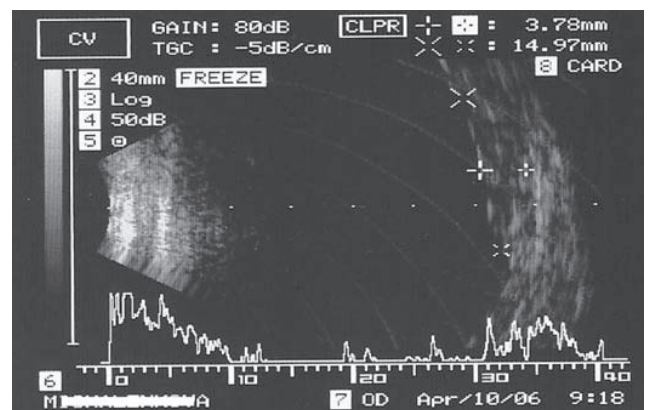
Ultrasound recording – Bscan – image of residual deposit under silicon oil with thickness of up to 3.8 mm more than 1 year after endoresection (in 2006)
